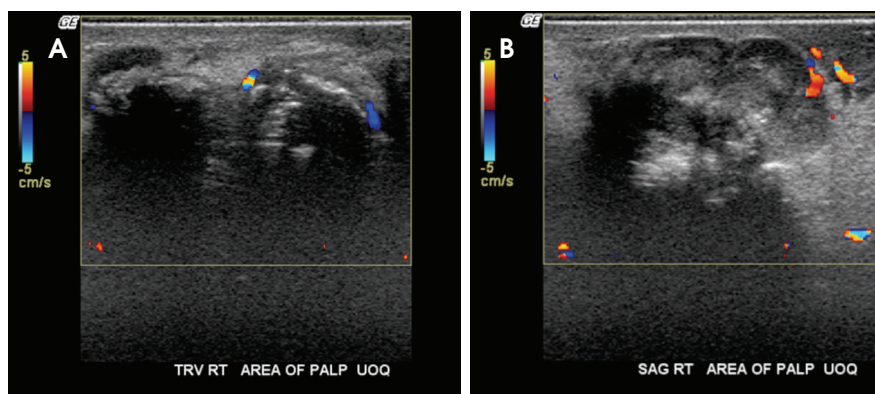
(A) Targeted ultrasound demonstrating a solid heterogeneous mass with posterior acoustic shadowing located in the upper outer quadrant. (B) Targeted ultrasound of the mass.
